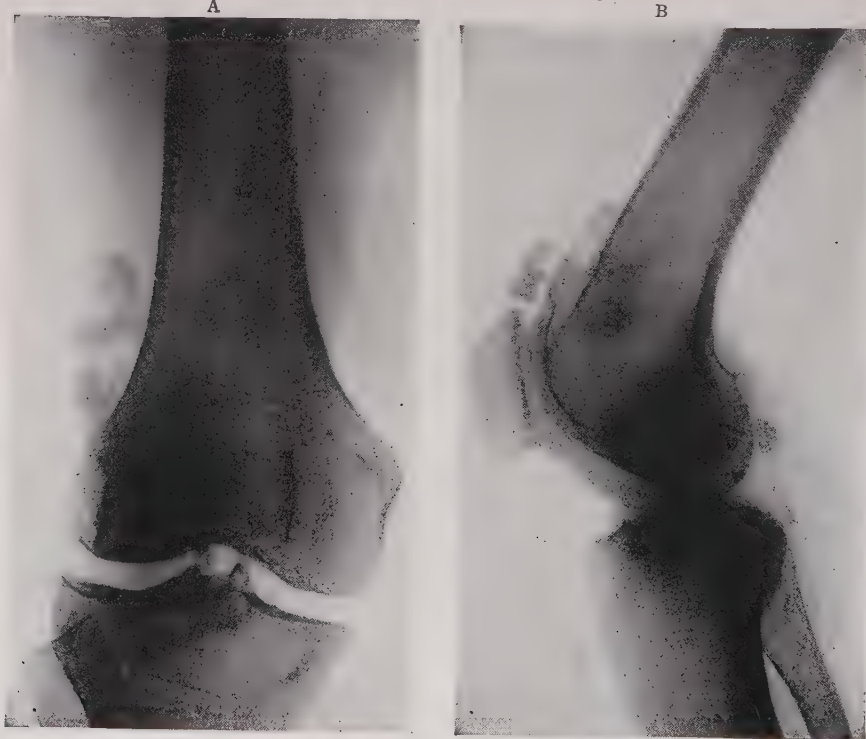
Roentgenogram showing loose bodies in the knee-joint. (A) Anterior view. (B) Lateral view.
